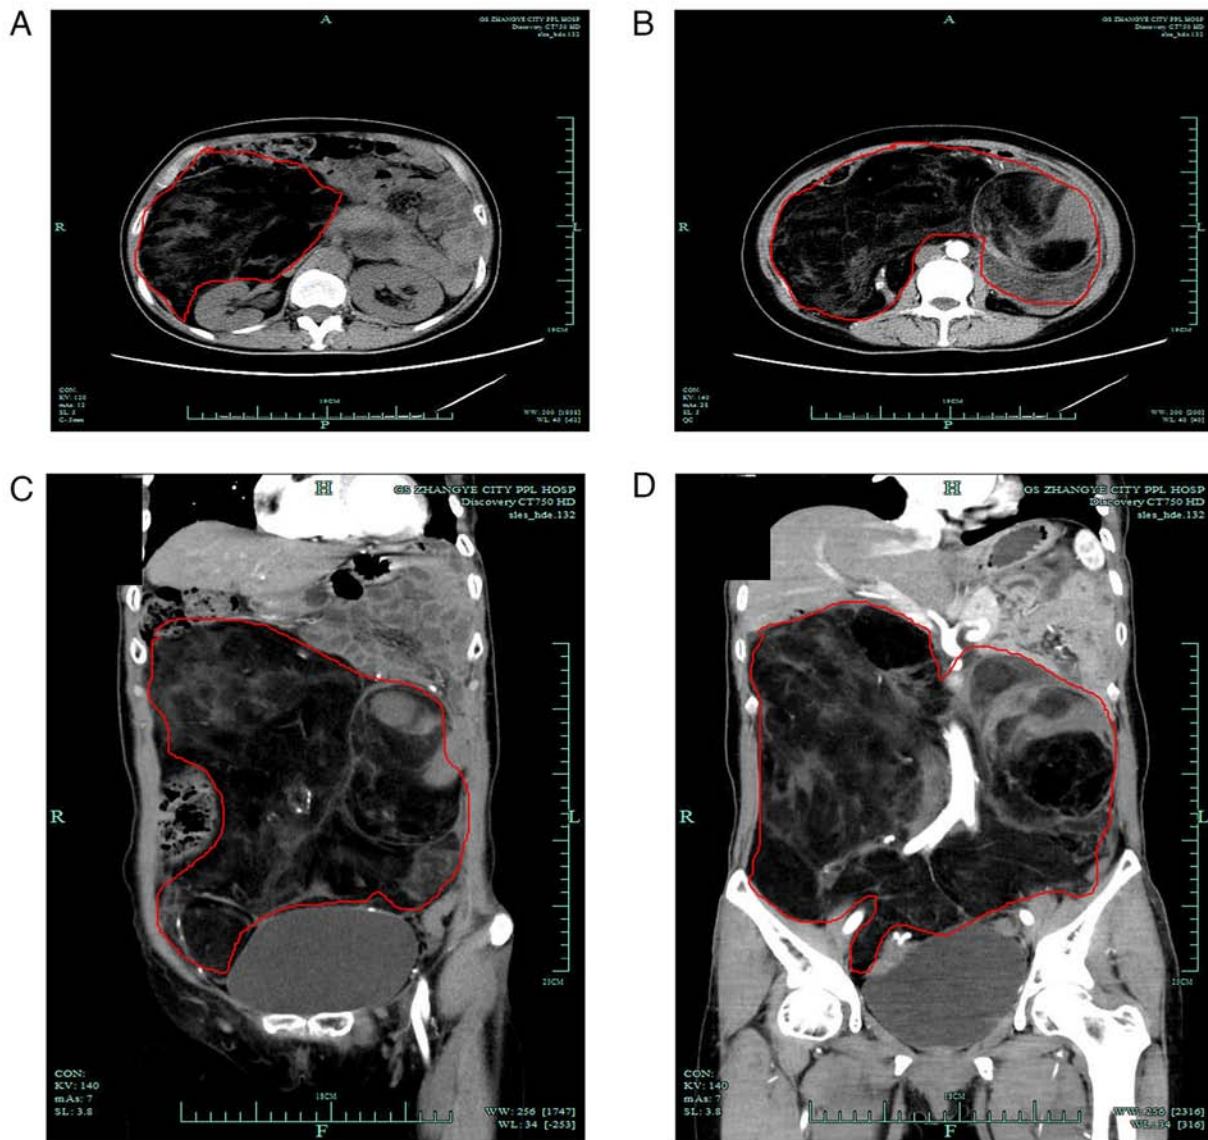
Preoperative CT images. (A) Cross section of giant liposarcoma. (B) Contrast-enhanced CT of giant liposarcoma. (C) Contrast-enhanced CT of giant liposarcoma in the sagittal view. (D) Contrast-enhanced CT of giant liposarcoma in the coronal view. CT, computed tomography.
